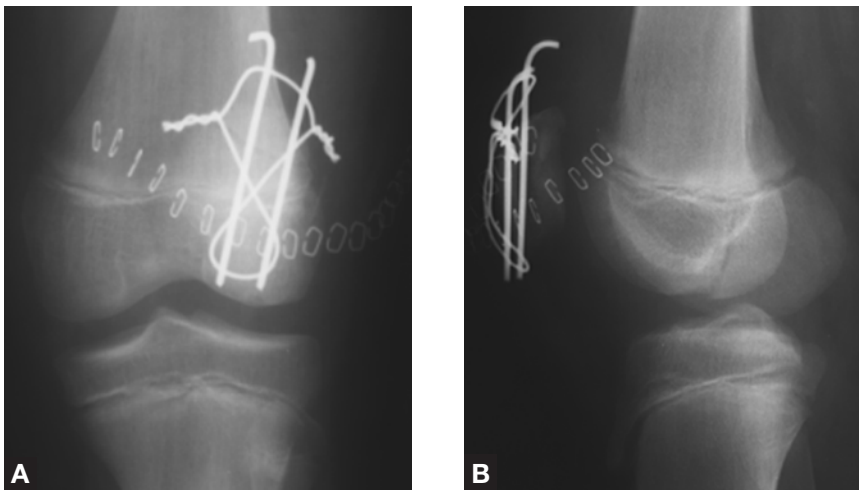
Case 1—Anteroposterior (A) and lateral (B) x-rays 11 days after open reduction and internal fixation of the patella fracture. Note the Salter III fracture line of the distal femur (not visible on prior x-rays).
